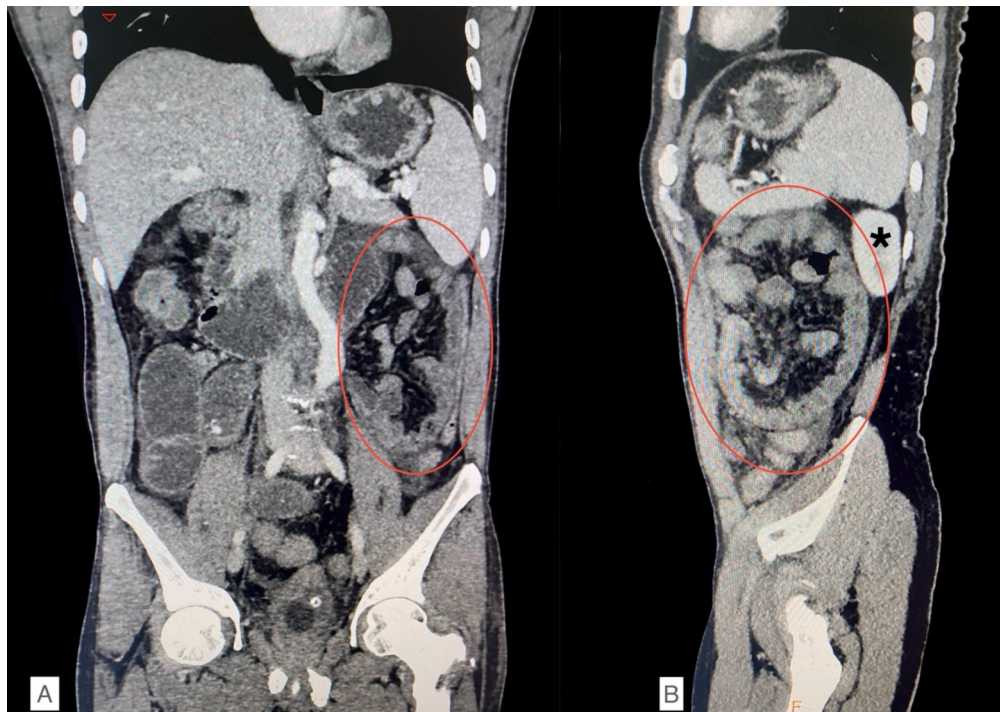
CECT Coronal section (A) showing red circle showing clustered, nondilated small bowel loops entrapped in the left upper quadrant with encapsulated appearance typical of a hernia sac. CECT Sagittal section (B) red circle outlines clustered small bowel loops, appearing sac-like. Loops are seen occupying a space anterior to the left kidney (asterisk), consistent with the anatomical location of a left paraduodenal hernia sac. CECT: Contrast-Enhanced Computed Tomography.
